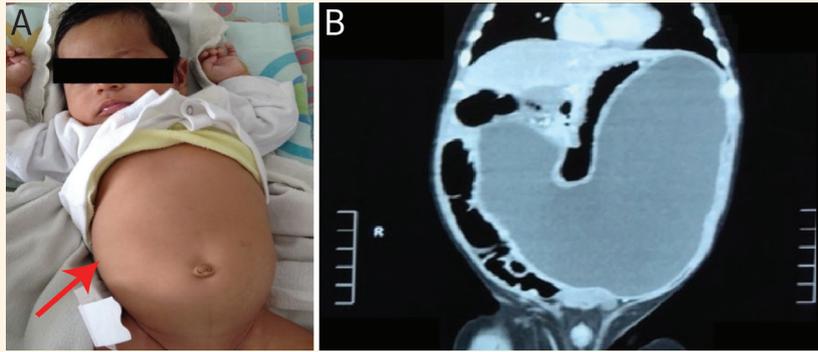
A: Photograph of a 2-month-old boy showing giant abdominal mass. B: Contrast computed tomography scan of the patient's abdomen showing a 11 × 12.8 × 6 cm mass with an approximated volume of 320 cc.
